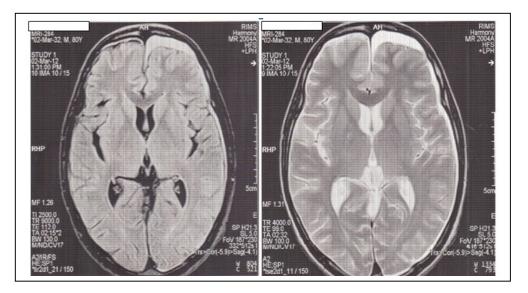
Axial T1 (left) and T2 (right) weighted images from an MRI scan of the brain showing CSDH over the left fronto-parietal-occipital region
